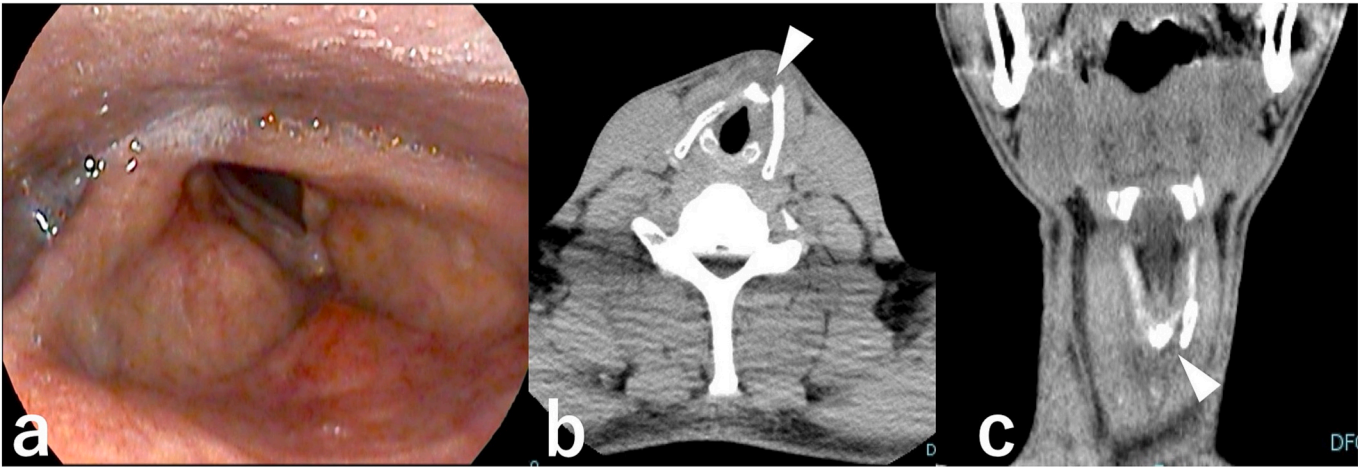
Initial laryngeal finding (a) and CT imaging (b,c). White arrow heads showed the thyroid cartilage fracture.
